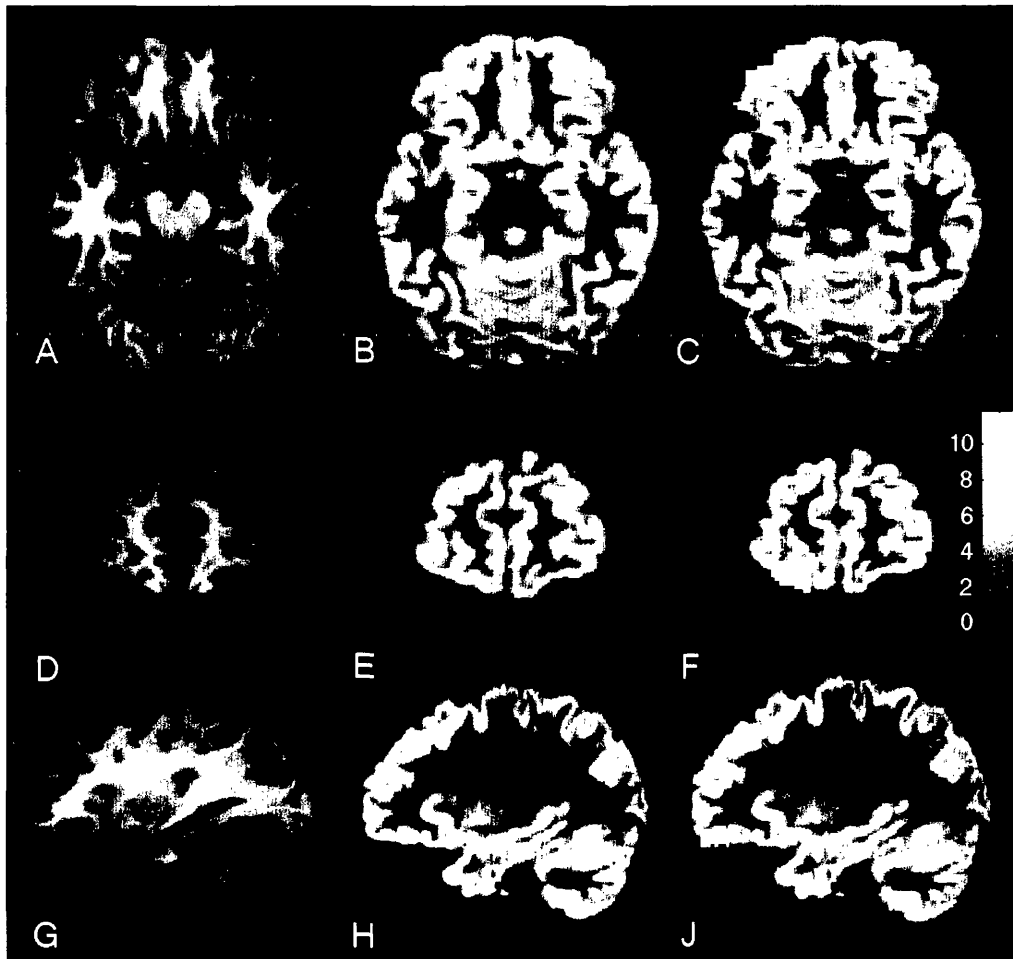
Patient 44, patient with left frontal lobe epilepsy and normal conventional MRI
